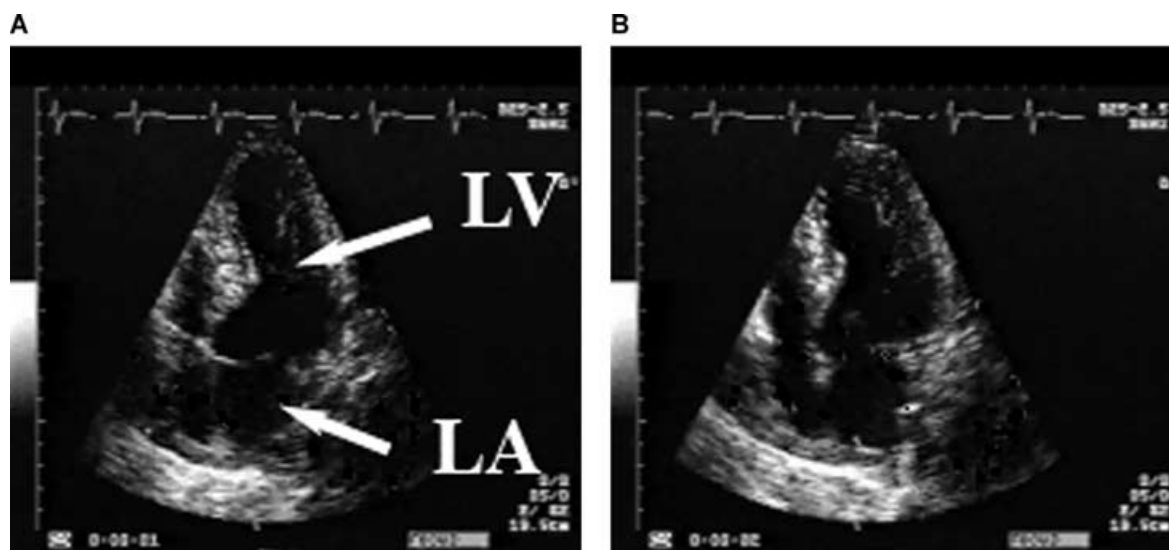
Apical four-chamber view at (A) end-systole and (B) end-diastole. A discrete area of apical hypokinesis was noted, but no definite thrombus was noted. A 2.5 MHz probe was used. LA = left atrium; LV = left ventricle.
